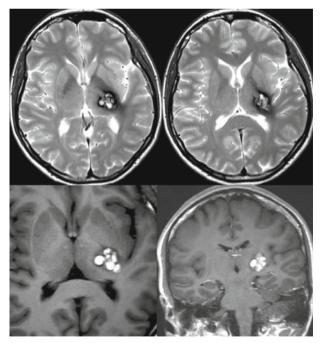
Preoperative MRI of a 43-year-old female suffering from right-sided hemihypaesthesia. The lesion measuring 18 mm in diameter involved the posterior limb of the internal capsule and the left thalamus and did not reach the surface of the left insula
